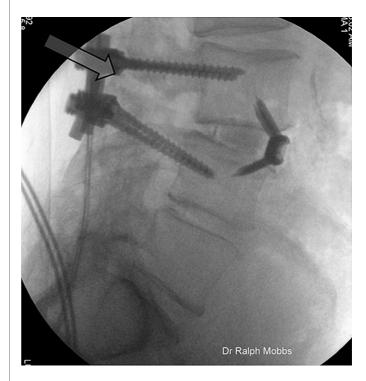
Lateral X-ray lumbar spine demonstrating an $L_{3,4}$ ALIF, performed 18 months following posterior fusion with non-union of the posterior elements (see arrow).
